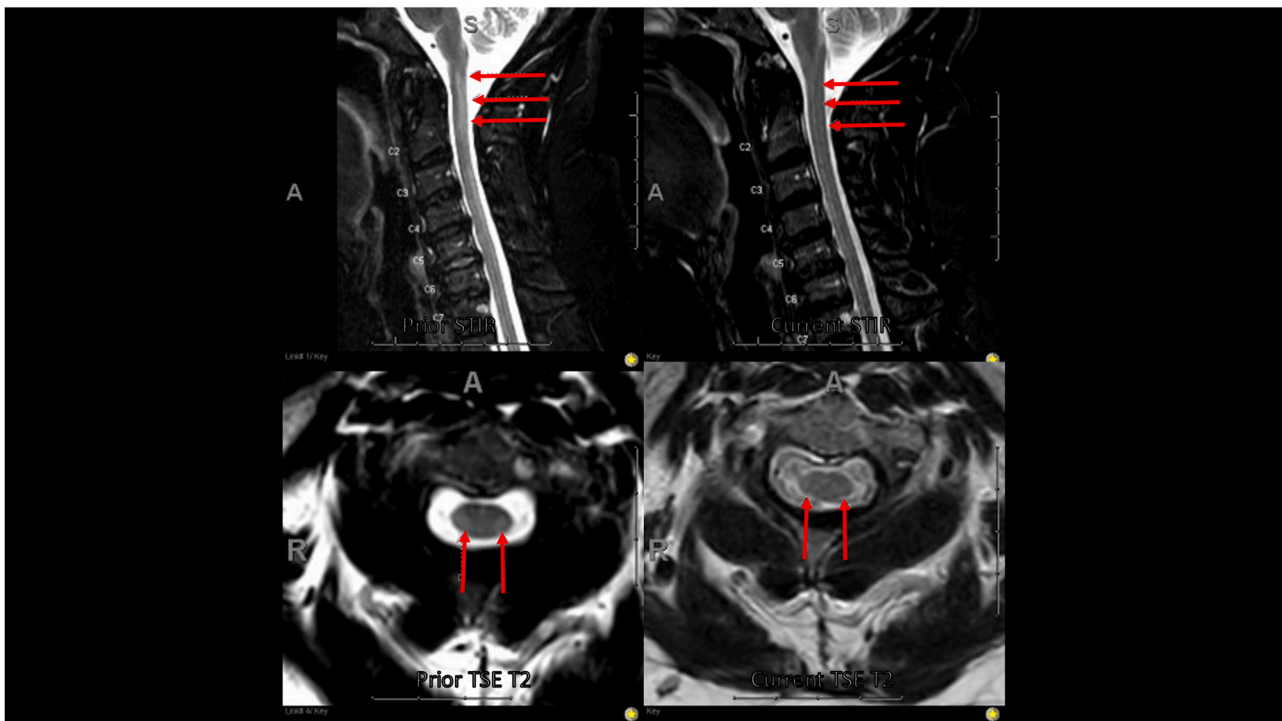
A): Significant improvement of the T2/FLAIR signal abnormality that had been seen involving the corticospinal tracts within the corona radiata extending to the posterior limb of the internal capsules bilaterally, without restricted diffusion or enhancement. (B): Progressive normalization of the high signal intensity that was previously seen within the cervical cord. No new areas of cord signal abnormalities have been identified.
